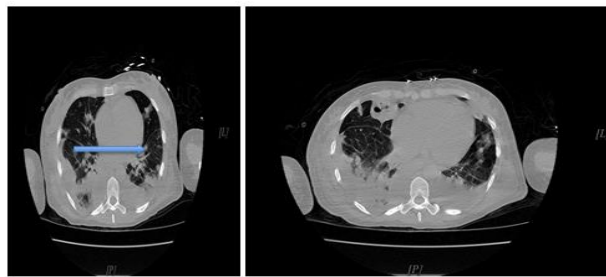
CT chest demonstrating enlarged pulmonary trunk with a pulmonary embolus visualized in the left posterior basal artery, multiple peripheral pulmonary nodules, cavities, and wedge-shaped consolidations and a feeding vessel sign or “a fruit on the branch sign “(a distinct vessel leading directly to a nodule or mass) indicative of septic pulmonary emboli was also demonstrated (blue arrow) . Bilateral consolidations, right greater than left, with mild to moderate pleural effusion on right.
